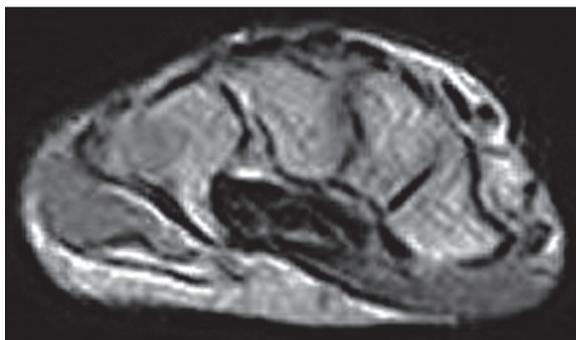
Axial T1 SE magnetic resonance image demonstrates normal wrist.
